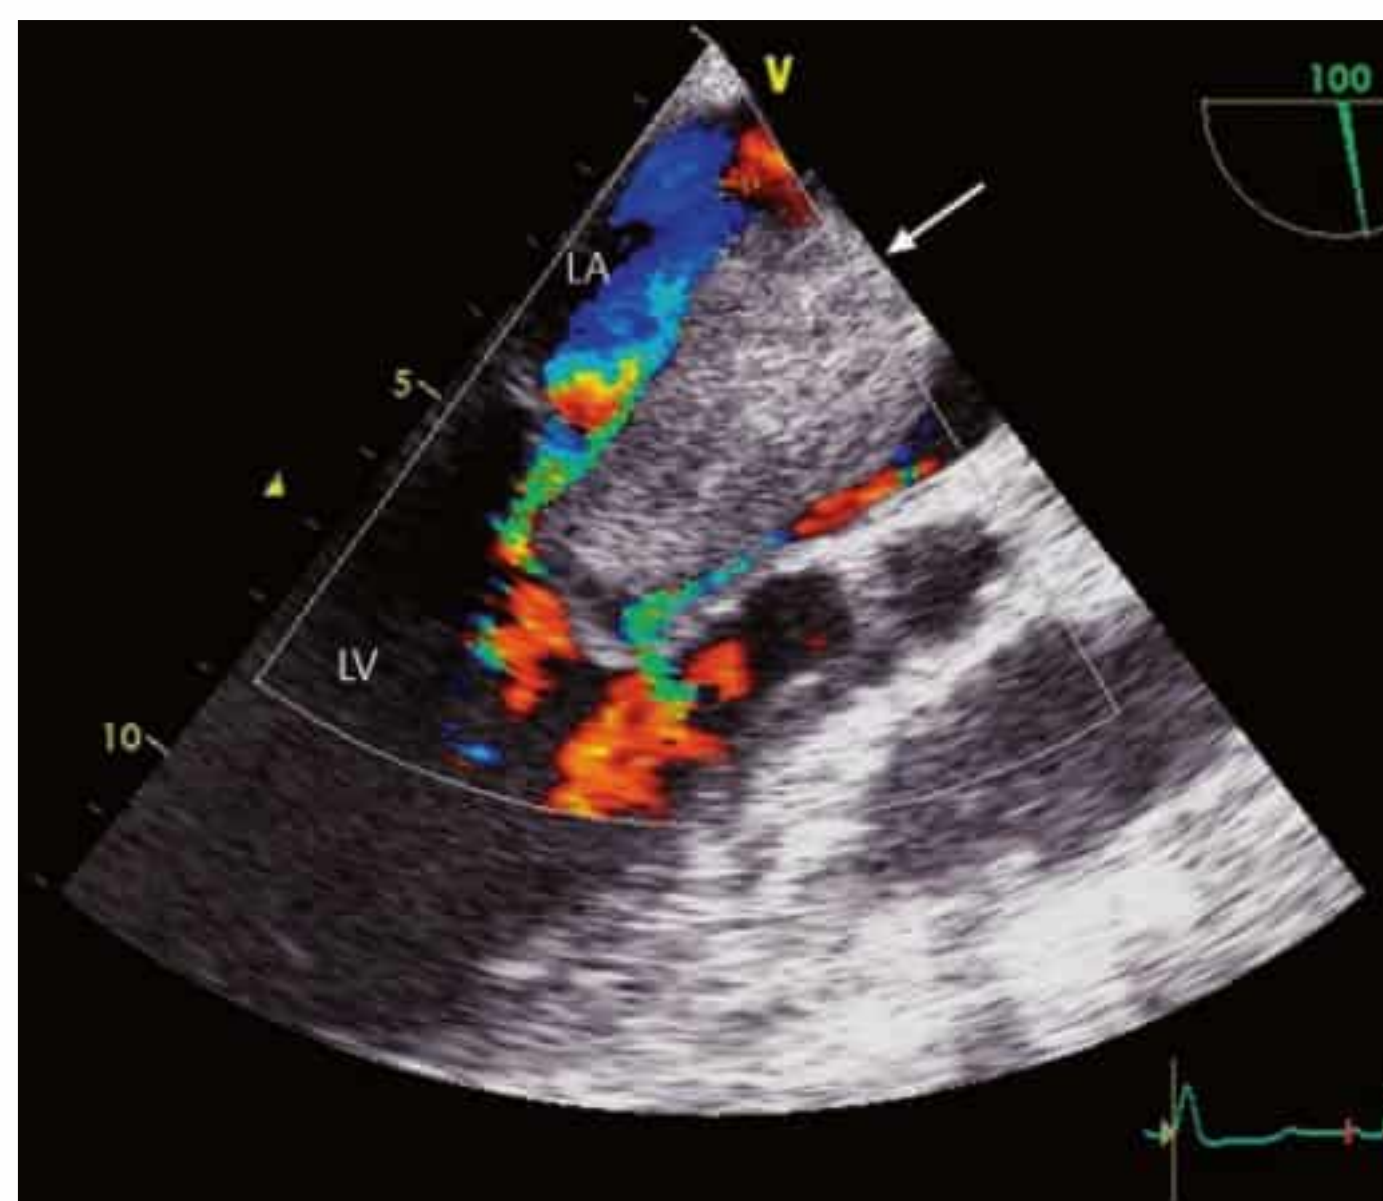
Functional mitral stenosis caused by a left atrial tumor (rhabdomyosarcoma, arrow) obstructing the mitral valve orifice in diastole. Color Doppler demonstrates the reduced flow through the constricted valve.
